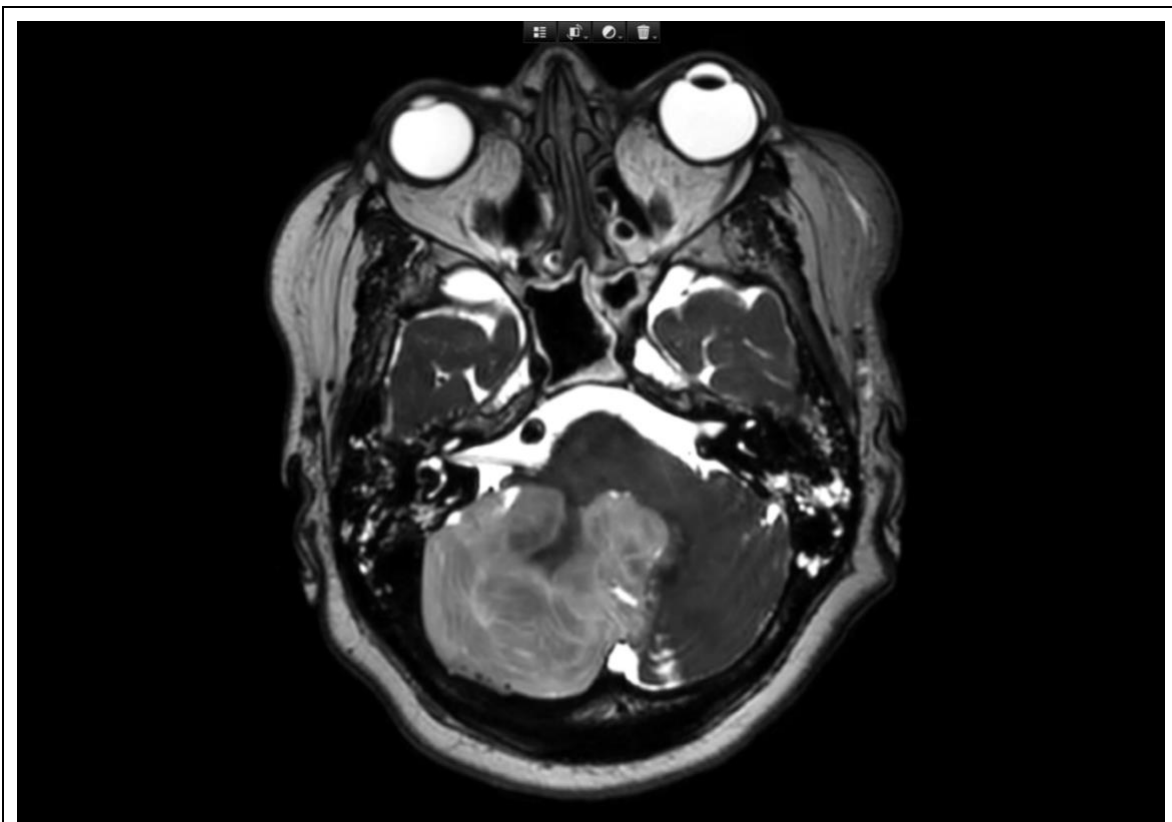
Axial MRI of the posterior fossa demonstrating a right-sided space-occupying infarction in the posterior inferior cerebellar artery (PICA) territory.
